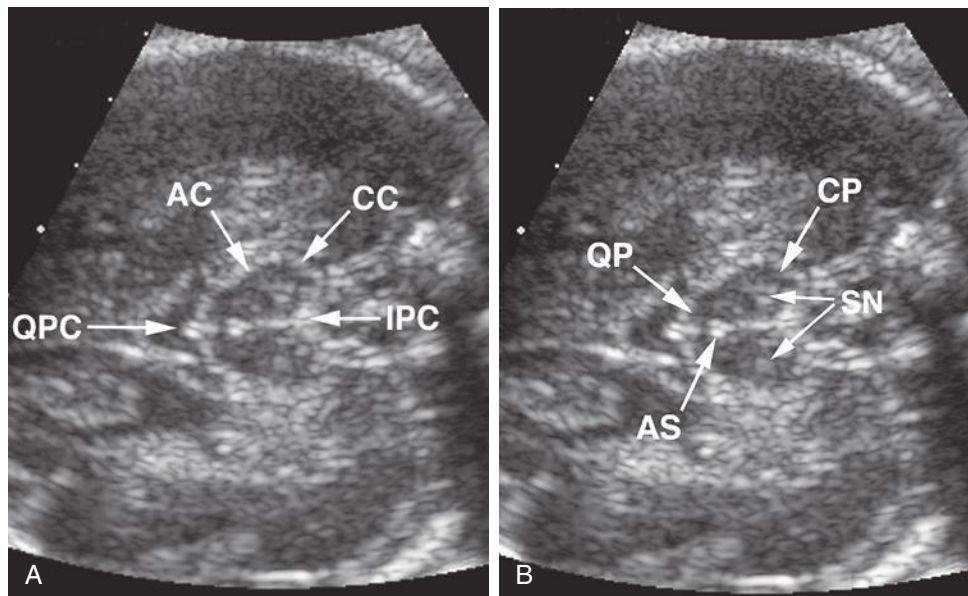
A and B, Sonograms demonstrating the midbrain. The midbrain is seen well because of the sharp outline provided by the brightly echogenic perimesencephalic cisterns (the leptomeninges provide the bright line of demarcation). These cisterns marginate the cerebral peduncles (CP) and the quadrigeminal plate (QP). AC, ambient cistern; AS, aqueduct of Sylvius; CC, crural cistern; IPC, interpeduncular cistern; QPC, quadrigeminal plate cistern. SN, substantia nigra.
